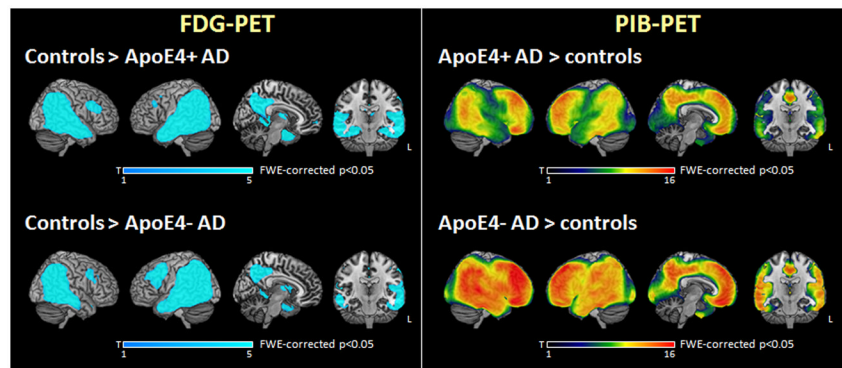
Patterns of glucose metabolism (FDG-PET) and amyloid deposition (PIB-PET) in ApoE4+ and ApoE4- AD patients compared with controls
